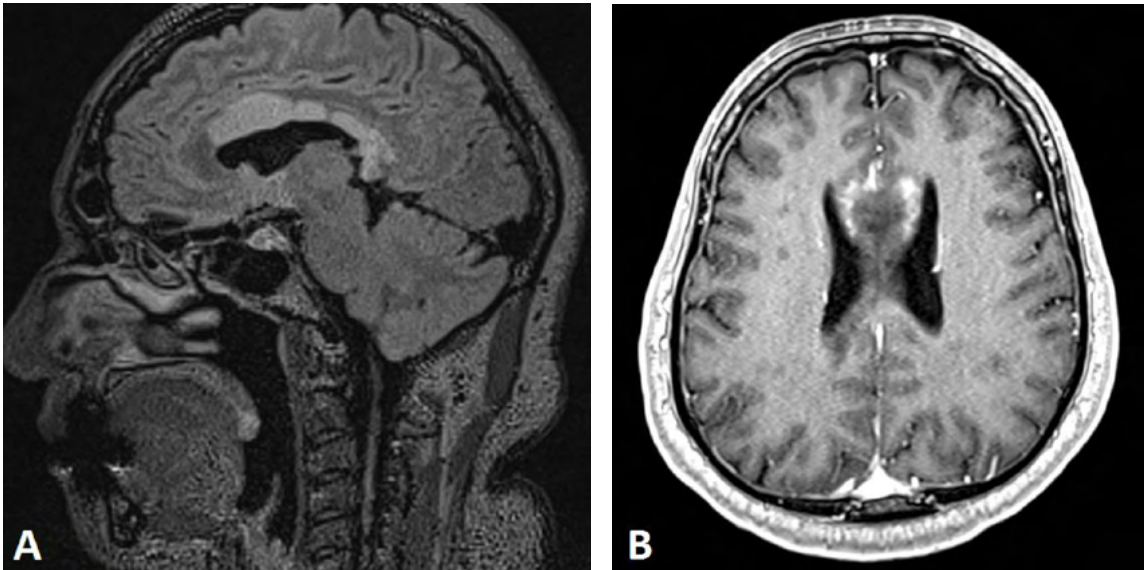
MRI. (A) Confluent lesion with FLAIR hyperintensity affecting the corpus callosum. (B) Incomplete annular enhancement pattern in the anterior portion of the corpus callosum, typical pattern of a demyelinating lesion.
